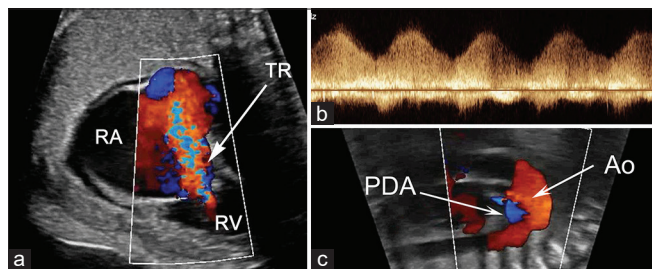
Fetal echocardiogram before maternal oxygen therapy. (a) Color Doppler demonstrating severe tricuspid valve regurgitation (TR, annotated by the white arrow). RA: Right atrium, RV: Right ventricle, (b) Spectral Doppler noting continuous pulmonary regurgitation. (c) Color Doppler of reverse flow (left-to-right) in the patent ductus arteriosus (PDA). Ao: Aorta
